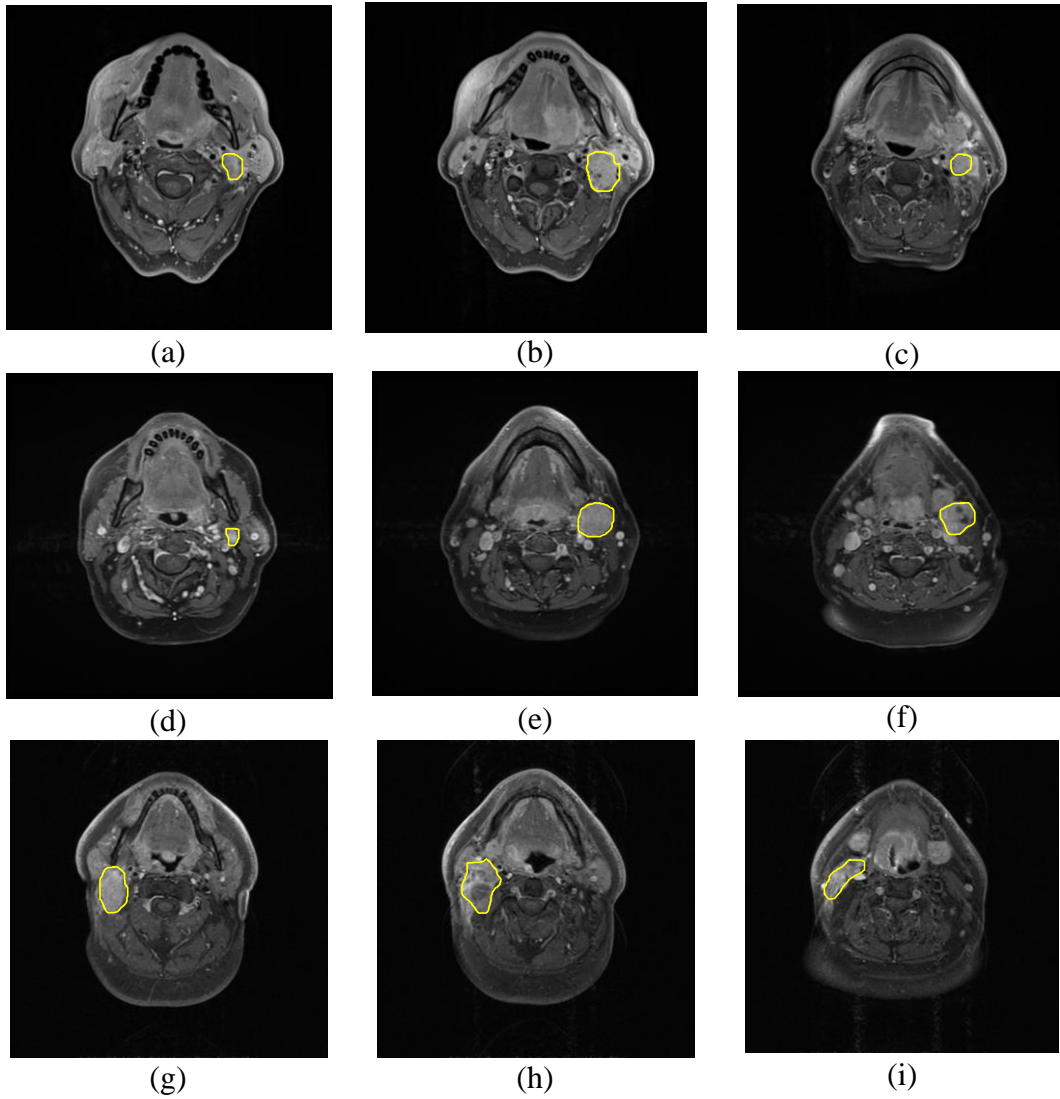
Examples of T1 axial MRI slices with ALNs marked by yellow. (a-c) are slices from top to bottom order of first patient. (d-f) are from second patient. (g-i) are from third patient.
